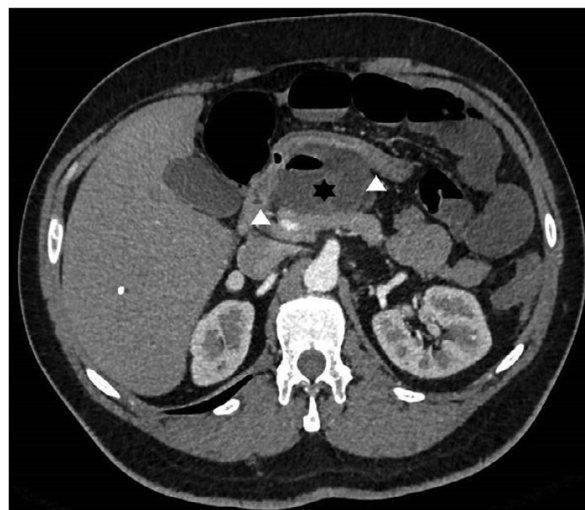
CT abdomen and pelvis suggestive of Unusual crowding of dilated and fluid-filled jejunal loops (black star) between the left liver lobe and the lesser gastric curve, dropping below and behind the stomach (white arrow)
